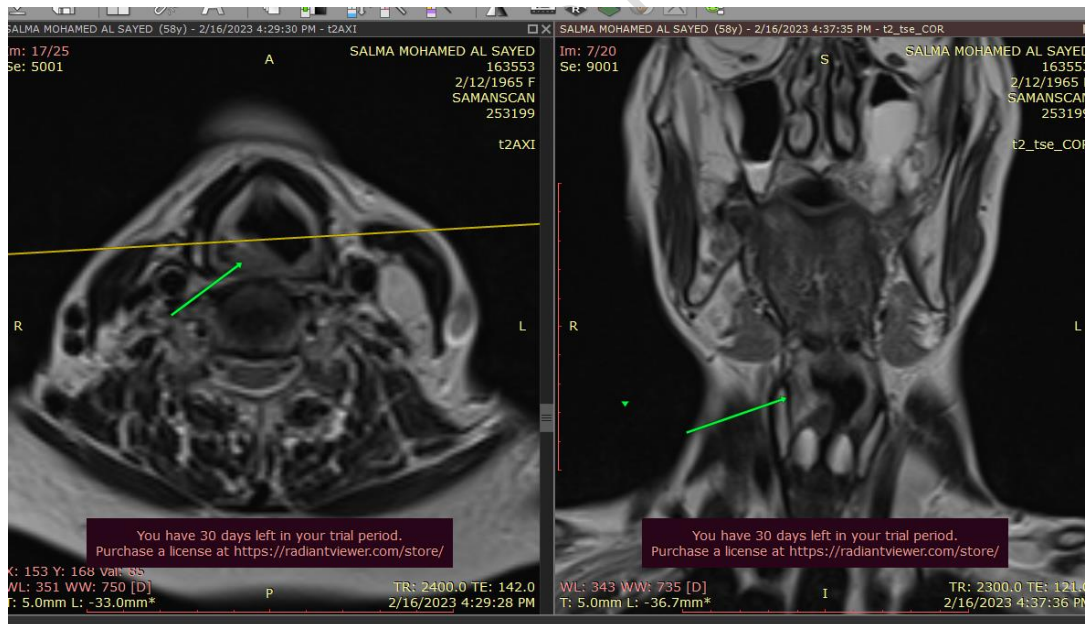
Axial T2WIs and coronal T2WIs MR images : Enlargement of the right piriform sinus , mild antero-medial deviation of the arytenoid cartilage(green arrow tagged structure) , relative widening of the right laryngeal ventricle and mild thickening and adduction of the right aryepiglottic fold are seen
